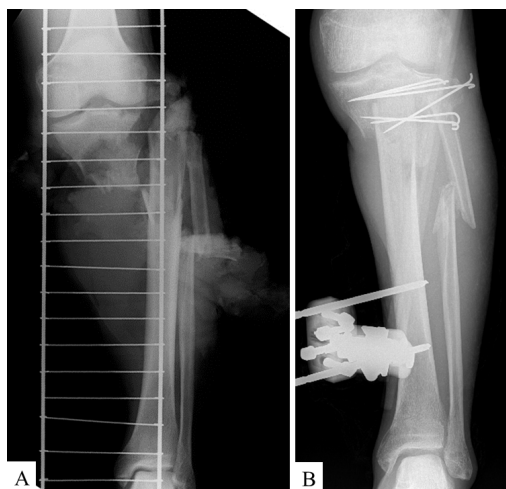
Case 1. (A) Proximal tibial fracture was observed on X-ray at the accident. (B) Emergency operation was performed with shortening, K-wire pinning, and fixation with Hoffmann external fixator at the same day as the accident
